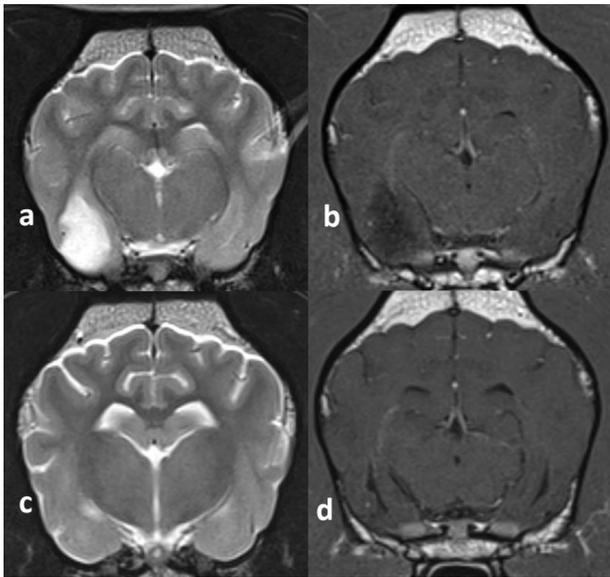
Transverse T2W (a) and (c), and T1W post-contrast (b) and (d), images of the brain. Images (a) and (b) represent the right piriform lobe mass, at the time of initial presentation (April 2020). Images (c) and (d) are from the MRI study acquired one year later, post-RT treatment (May 2021).
